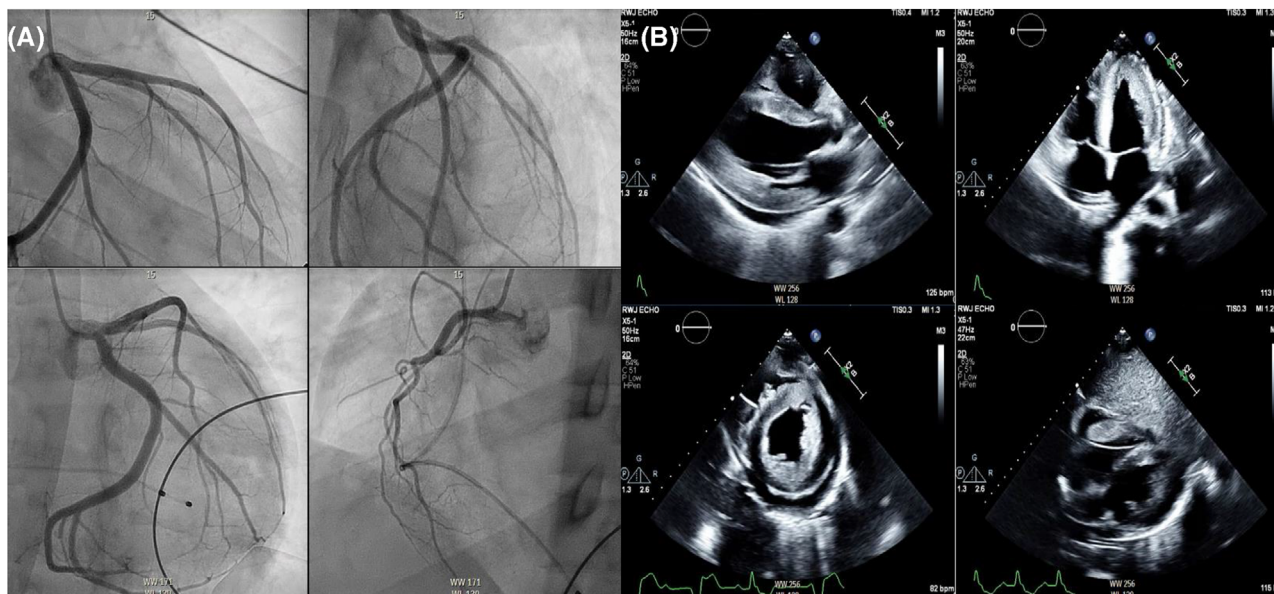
Left heart catheterization and transthoracic echocardiogram
